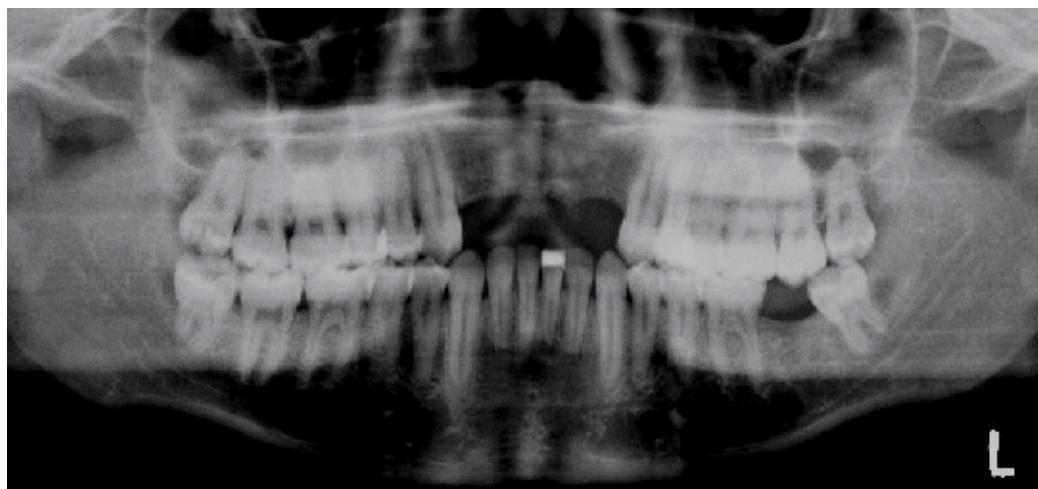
Case 2: orthopantomogram
